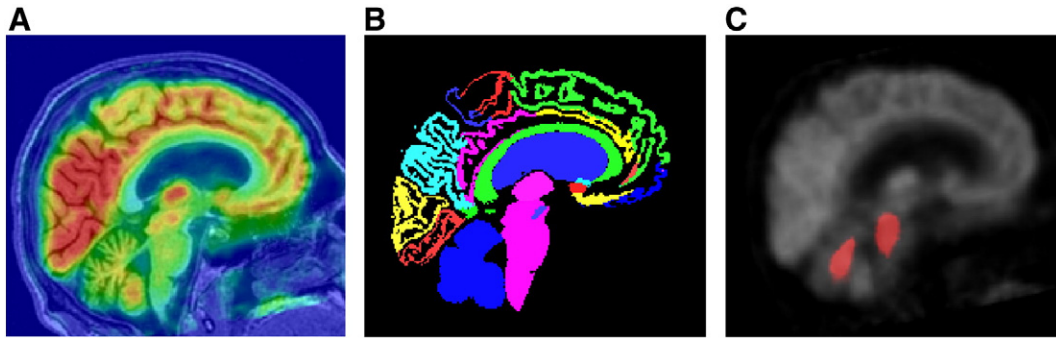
Typical examples of the images required for regional feature extraction from the baseline images of a HC subject. From left to right: baseline MRI overlaid with baseline FDG-PET; masked anatomical segmentation; baseline FDG-PET overlaid with normalisation cluster. The regional colour map for the segmentation is as used in Gousias et al. (2008).
